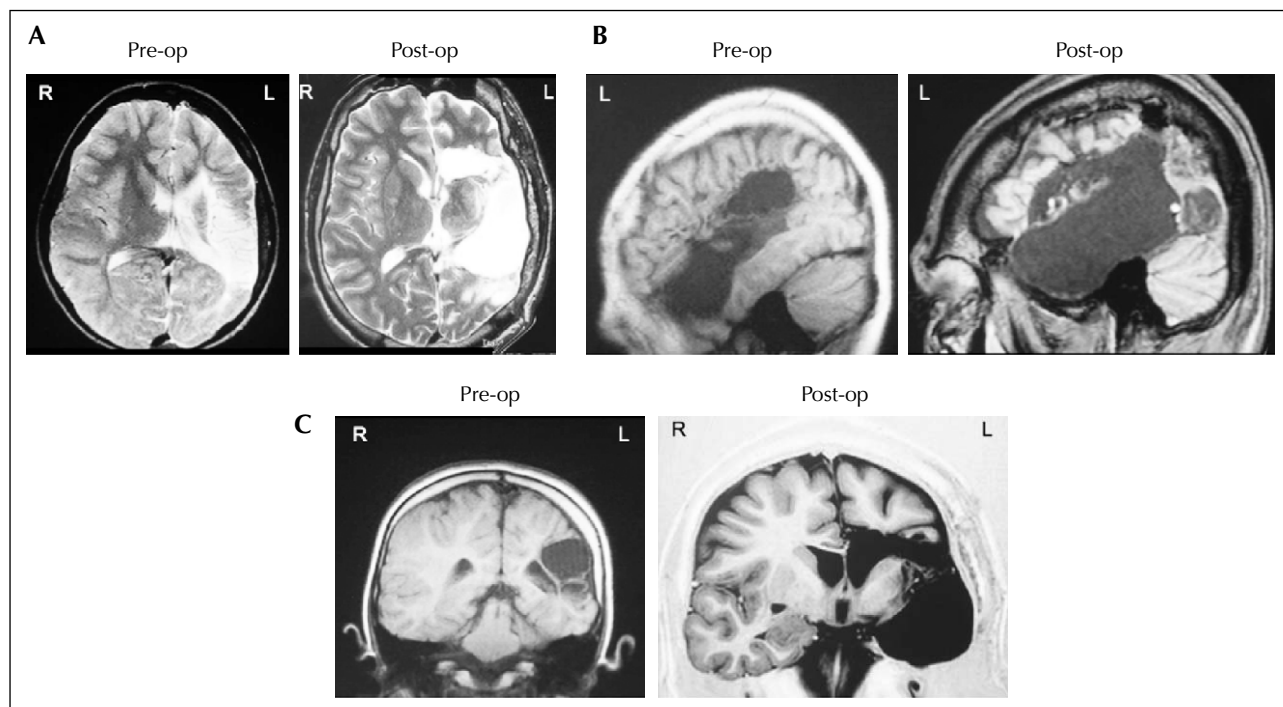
Pre- and post-operative magnetic resonance imaging (MRI) findings in patient 4. Comparable slices are displayed in parallel resembling the pre-operative (pre-op, left side) and post-operative (post-op, right side) status according to axial T2-weighted, thickness 2.0 mm (A) and sagittal T1 weighted, thickness 3.5 mm (B) and coronal T1 weighted inversion recovery (C) images. Scans were performed on a 1.5 Tesla Siemens Magnetom MRI Scanner.
